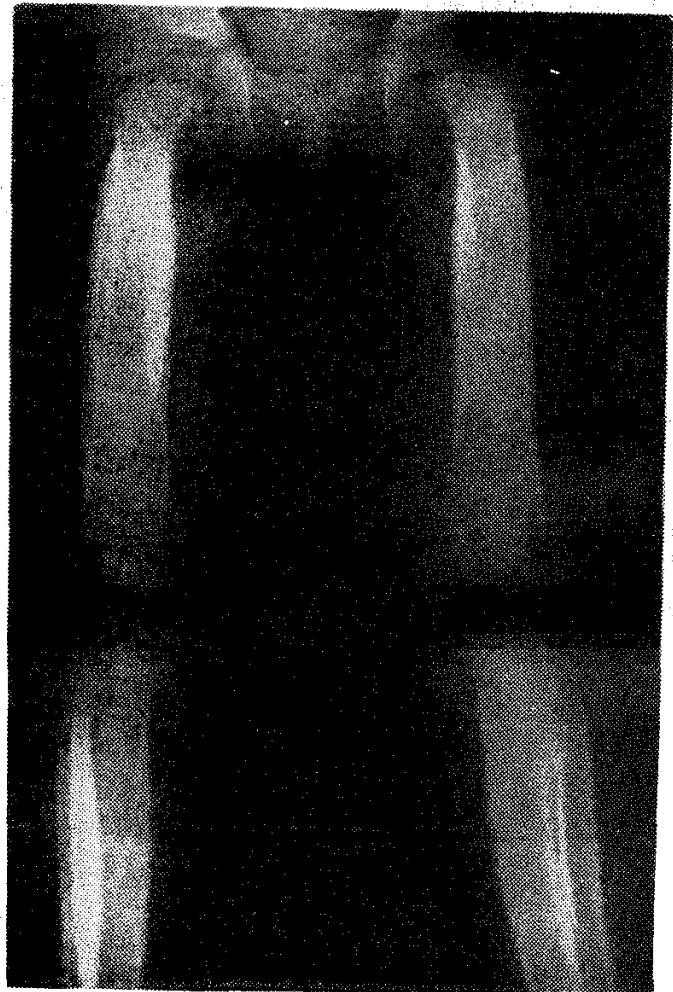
Lower extremity AP radiograph shows florid periosteal reaction along the diaphysis of long bones. Lateral bowing of left leg present.
